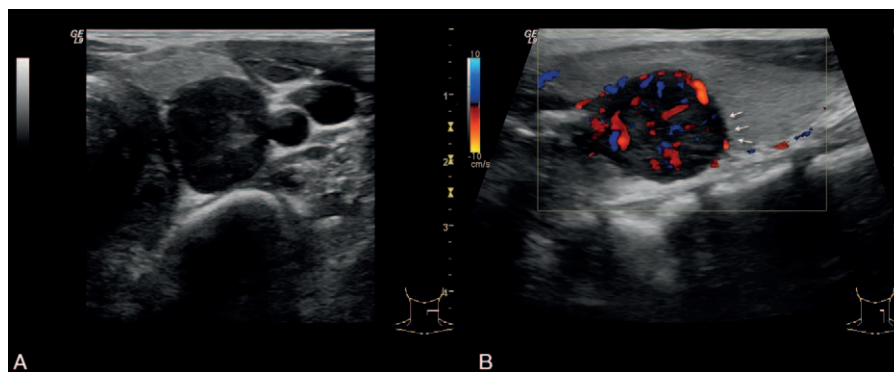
Neck ultrasound imaging. (A) Transversal sonogram showed a 2.3 × 1.7 cm round hypoechoic nodule posterior to the left thyroid lobe. (B) Color Doppler sonogram showed increased vascularity in the nodule. Spicule sign (arrows) was observed on longitudinal plane during a second review of ultrasound images postoperatively.
